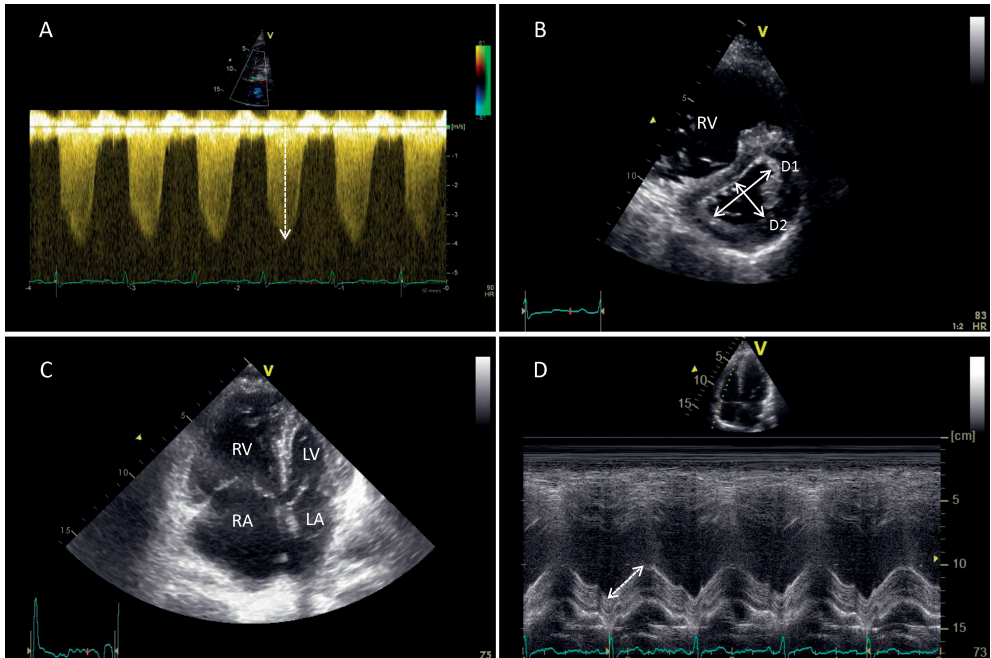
Echocardiographic signs of pulmonary hypertension. (A) Continuous wave Doppler image showing the velocity curve of the tricuspid regurgitation jet. The maximal velocity in this figure is 4.0 m/s. (B) Systolic flattening of the interventricular septum. The eccentricity index is calculated by $D1/D2$ and in this example is >1 , indicating increased right ventricular pressure. (C) Apical 4-chamber view with an enlarged right ventricle that forms the apex and a small left ventricle. (D) M-mode of the tricuspid annulus. The systolic movement towards the apex (tricuspid annular plane systolic excursion, TAPSE) is 28 mm, which indicates normal function.
